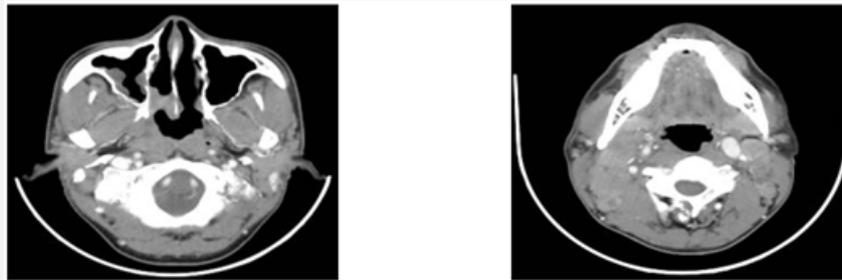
Pre-treatment enhanced CT image: (a) nasopharyngeal carcinoma with posterior nasal cavity and right cavernous sinus infiltration; (b) both side lymph node metastasis at level II, III, IV.
